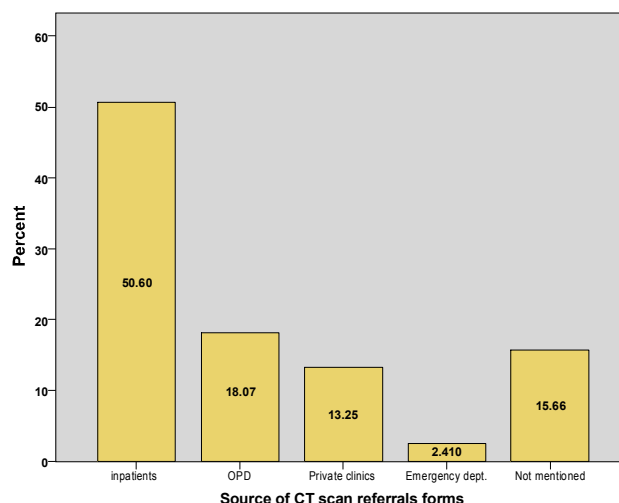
Source of CT scan request forms
